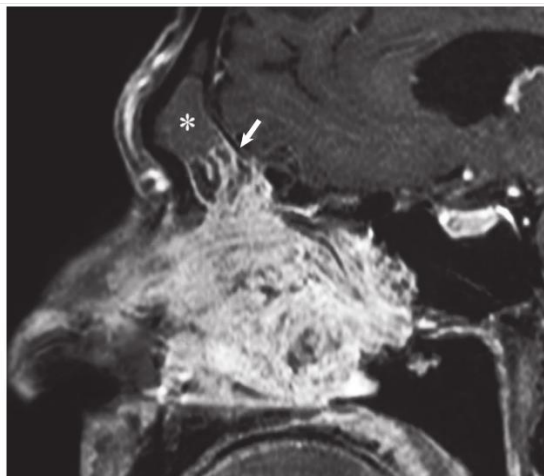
Inverted papilloma on a sagittal contrast-enhanced magnetic resonance image. The advantage of this acquisition plane is the excellent assessment of tumor growth into the most caudal part of the frontal sinus. The upper part of the sinus is filled with inflammatory secretions (*asterisk*). The sagittal plane also permits accurate evaluation of the relationships between the tumor and the floor of the anterior cranial fossa, which is not invaded (*arrow*).
